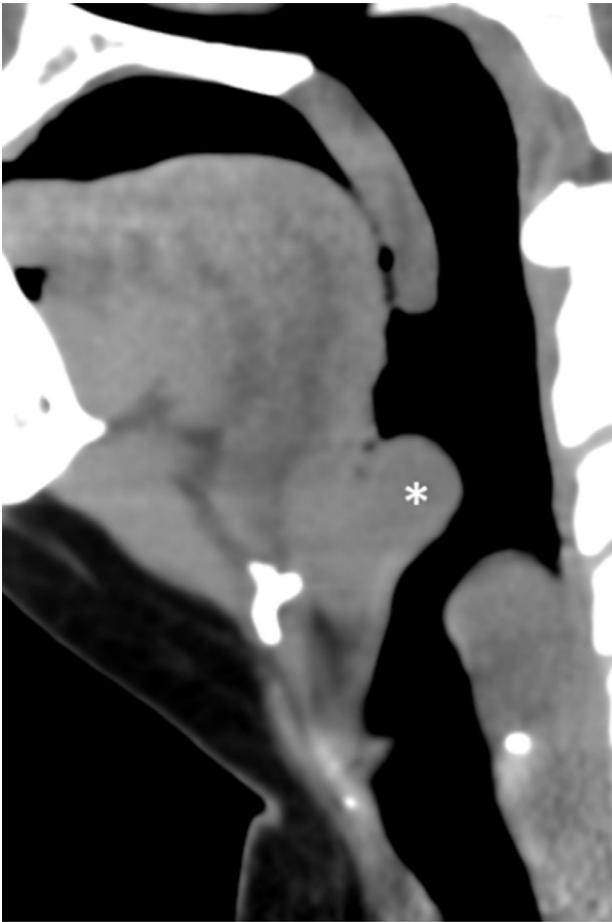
Epiglottitis. Thirty-eight-year-old female presenting with fever and sore throat. Sagittal reconstruction of CT neck reveals enlarged and edematous epiglottitis (*) consistent with epiglottitis.
